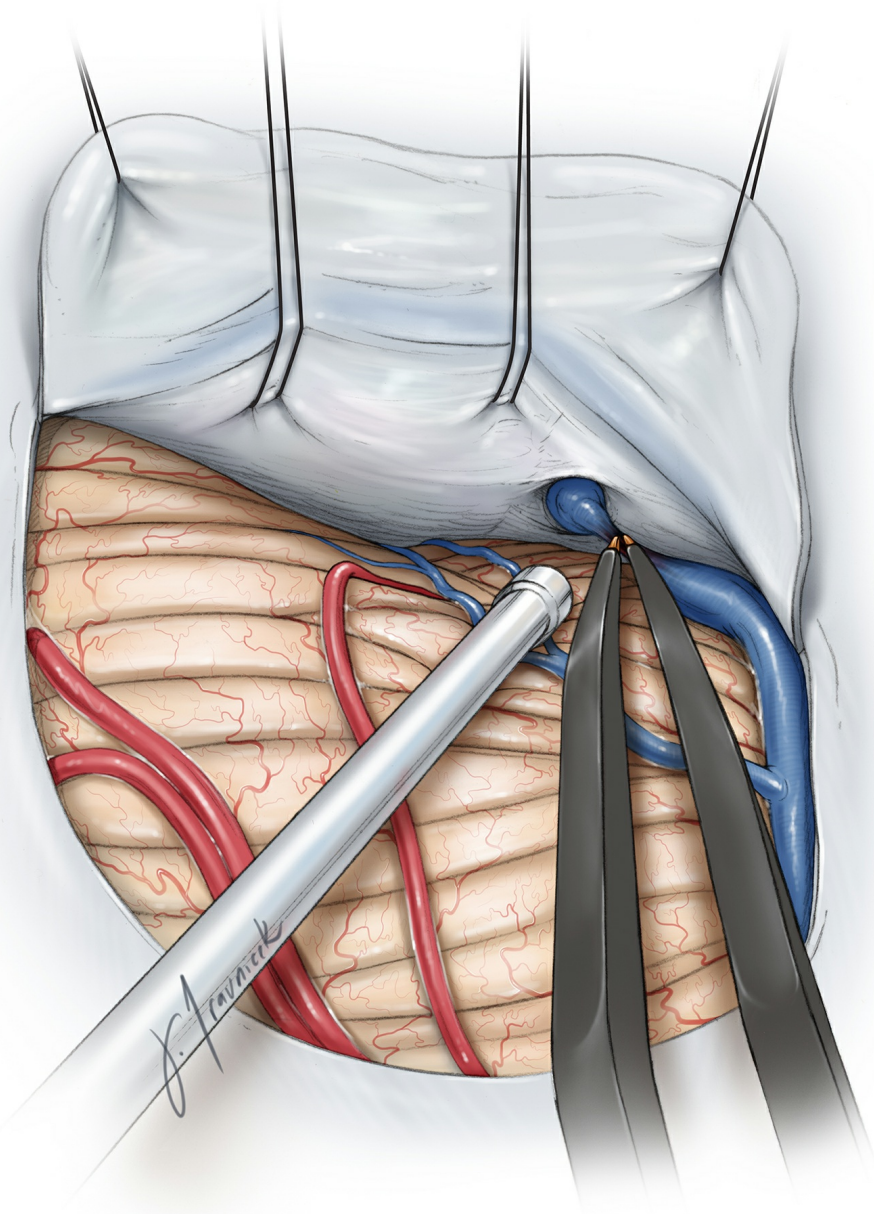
One or two paramedian bridging veins may have to be sacrificed. Large midline bridging veins are left intact. Note the retraction sutures placed through the posterior tentorium. These sutures gently rotate and mobilize the transverse sinuses superiorly. Microdoppler ultrasonography can confirm the patency of the sinus and gauge the safe degree of retraction on the sinus.
